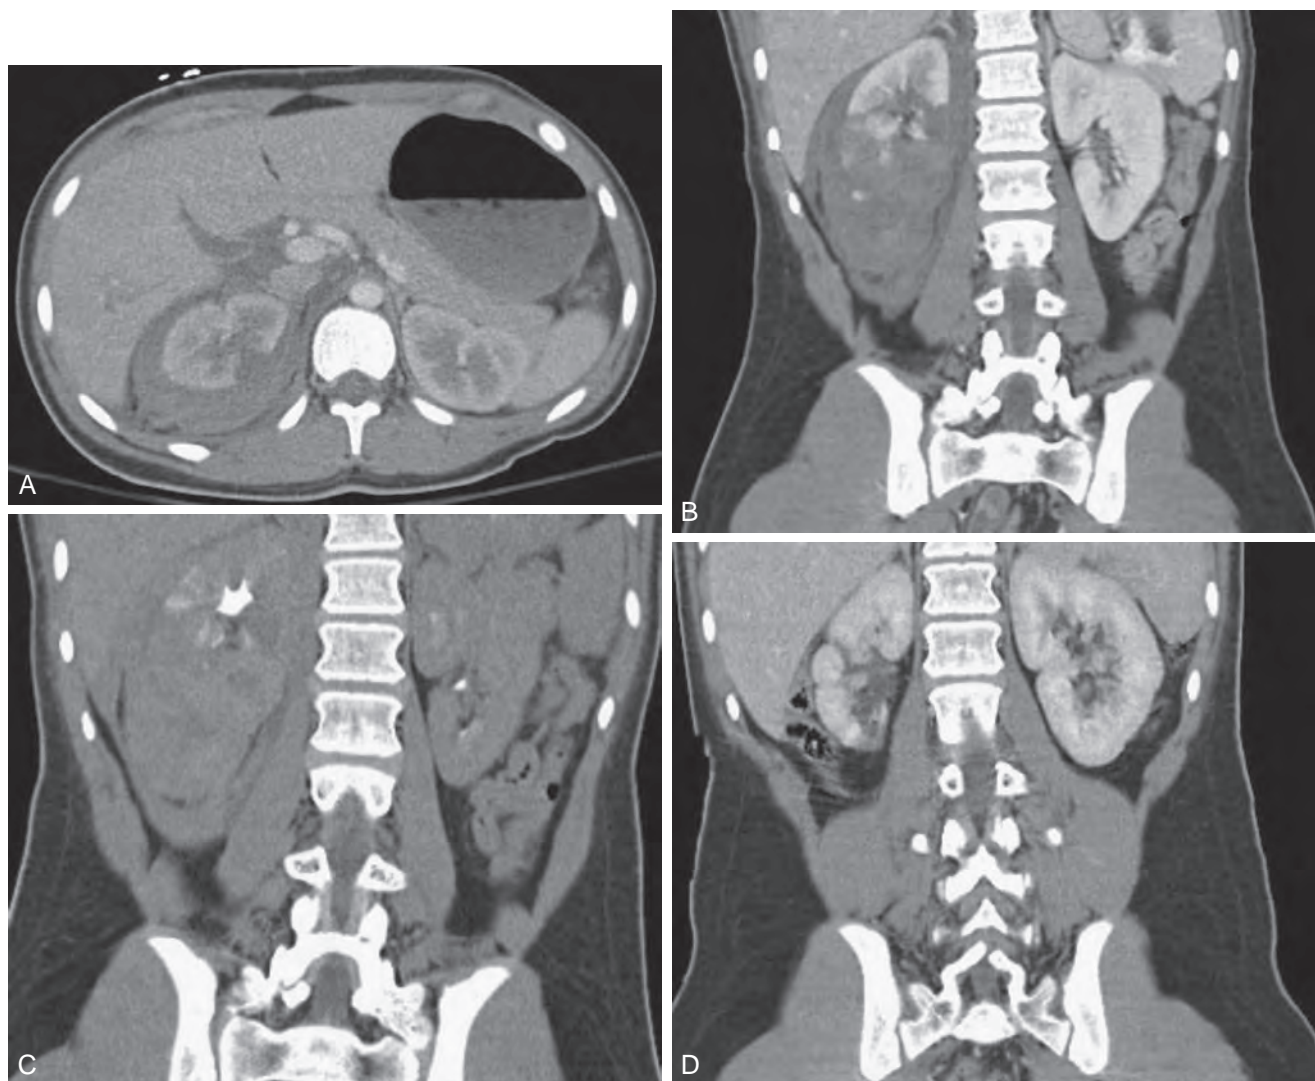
Computed tomography (CT) images of grade 3 right renal trauma—acute, delayed, and at 3-month follow-up. A, Acute CT image of grade 3 renal trauma showing greater than 1-cm laceration of midrenal pole with perinephric hematoma. B, Acute CT image coronal reconstruction of grade 3 renal trauma, with possible devitalization of the entire lower pole of the kidney. C, Two-hour delayed CT image coronal reconstruction of grade 3 renal trauma, with no urinary extravasation noted and lower pole with questionable devitalization versus contusion. D, CT image coronal reconstruction 3 months after traumatic injury revealing parenchymal scarring at site of laceration with scarred but functional lower pole consistent with healed parenchyma following severe renal contusion. Scarring of lower pole was believed to have occurred with impoverished blood supply owing to severe contusion.
